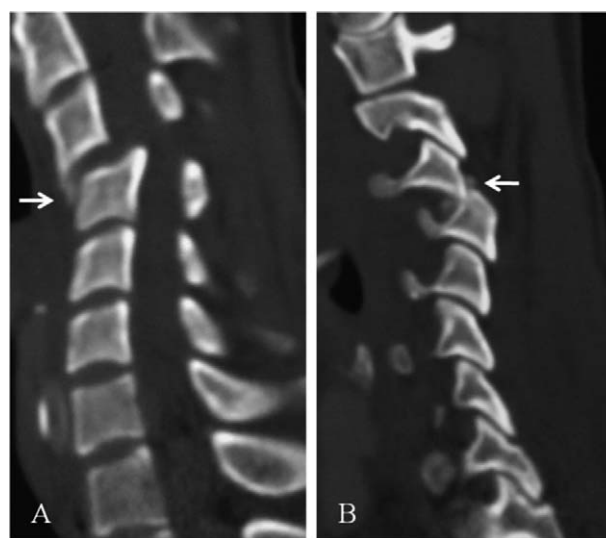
A 36-year-old male patient presenting 12 weeks after injury with C3–C4 dislocation. (A and B) The sagittal reconstruction CT images showed signs of bony fusion between the adjacent vertebral bodies and around the locked facets (the arrow). CT = computed tomography.
